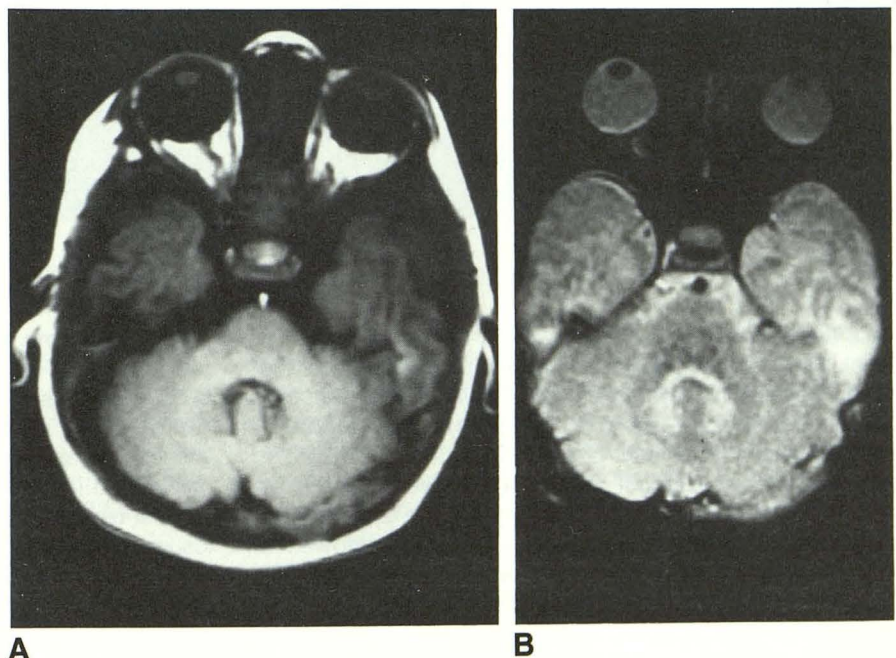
A and B, 1-month-old infant. Axial T1-weighted, 600/20 (A), and T2-weighted, 2500/80 (B), images. Cerebellar peduncle has increased signal intensity on T1-weighted image and decreased signal intensity on T2-weighted image secondary to myelination.
